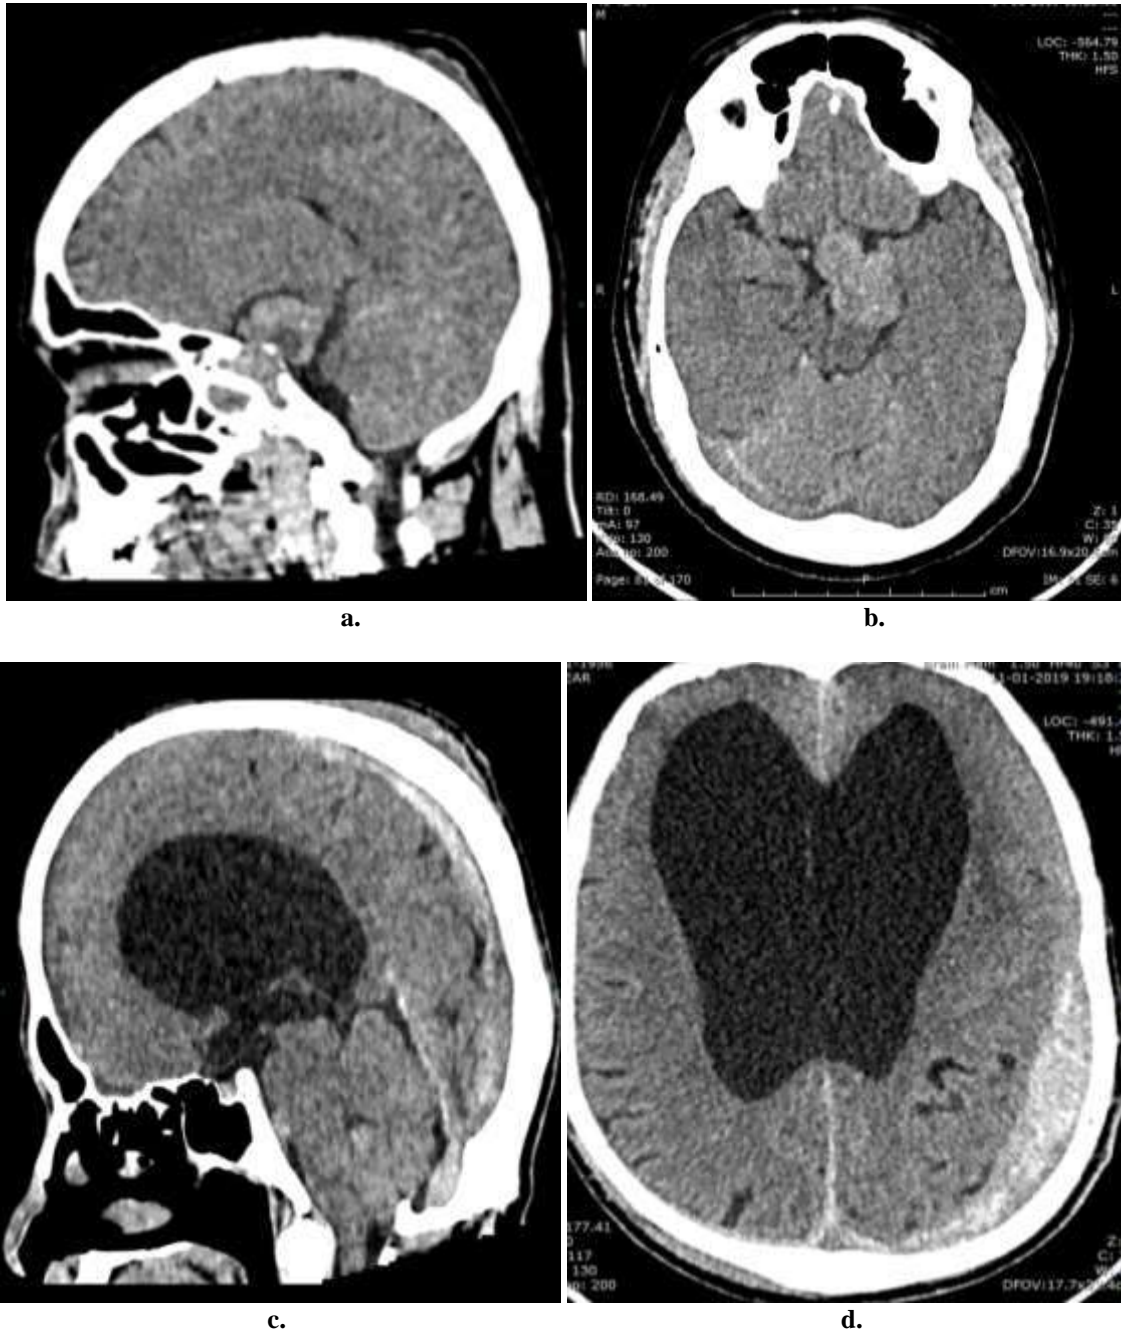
A 38 year old female underwent CT brain for head injury shows soft tissue swelling in right parietal scalp (a) with incidentally detected pituitary macro adenoma (b). A 72 year old male patient with head injury shows left parietal scalp swelling (c) showing obstructive hydrocephalus at 3rd ventricle and left parietal subdural hemorrhage (d).
